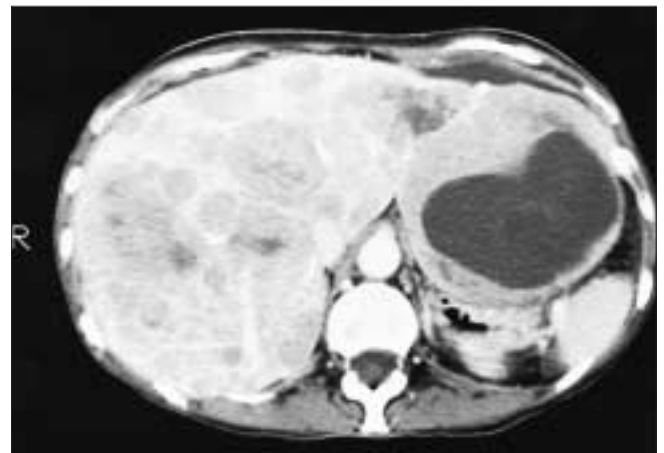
CT scan demonstrating liver metastases from a midgut carcinoid.
